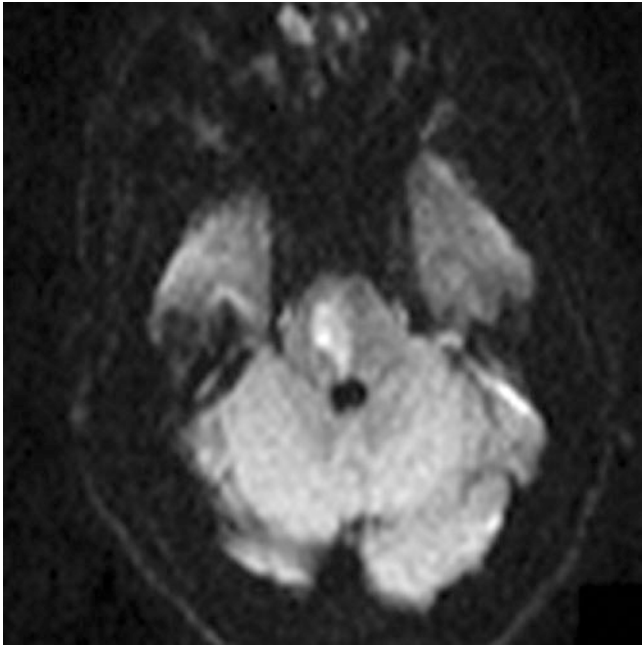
Paramedian pontine infarction. DWI shows acute infarction of right pons in the basis pontis extending to the tegmentum and floor of fourth ventricle. The infarction does not cross the midline and lateral pons is spared, presumably due to occlusion of the paramedian pontine perforating artery
